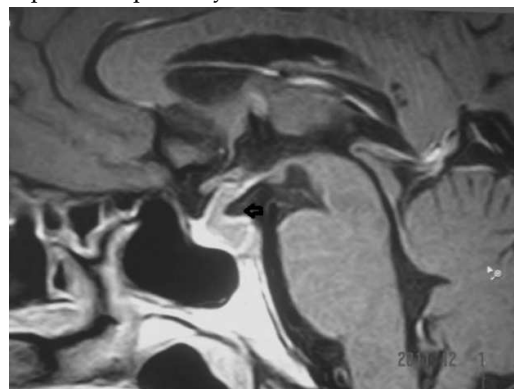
Magnetic resonance Imaging showing thickening of the pituitary stalk and absence of the bright spot (Arrow head).
